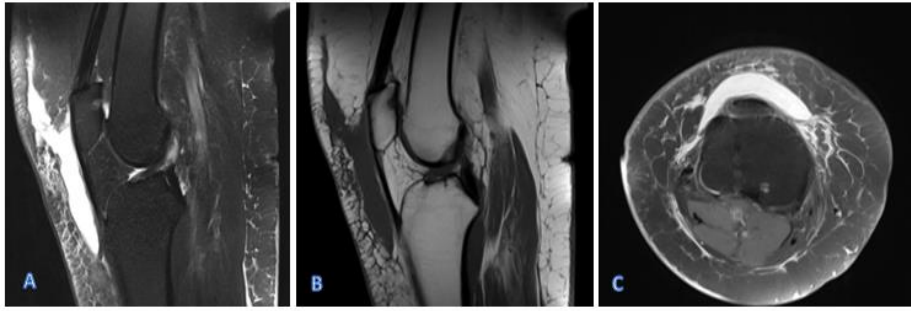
In the sagittal plane (A, B), a 14x3 cm fusiform/ovoid-shaped fluid collection is observed in the prepatellar region, located within the deep subcutaneous fat tissue with an epifascial distribution. The lesion appears hyperintense on T2-weighted sequences (A), hypointense on T1-weighted sequences (B), and hyperintense on PD-weighted images (C). No effusion is detected in the adjacent knee joint. Musculo-tendinous structures were intact.
